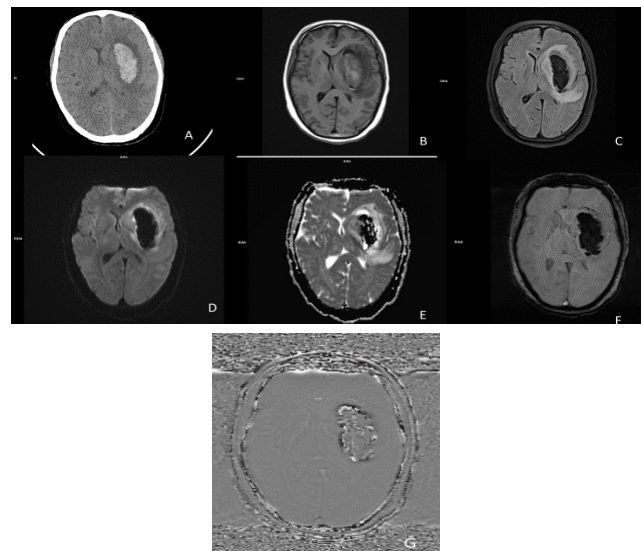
Gangliocapsular bleed on MRI. (a) Axial section NCCT head (b) shows hyperdensity in the left ganglio-capsular region appearing heterogeneously hyperintense on t1 (c) and hypointense on flair (d) showing no obvious diffusion restriction on DWI and (e) ADC (g) with areas of susceptibility on SWI (f) and corresponding hyperintensity on phase images
